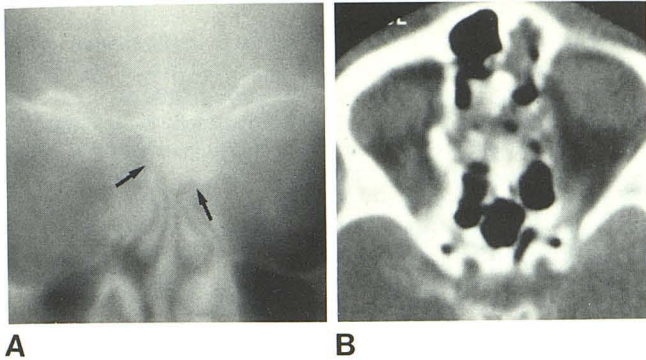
Right posttraumatic rhinorrhea, case 15. A, Frontal polytomogram. Left clouded ethmoidal cells (arrows) but no patent abnormality of lamina cribosa. B, Axial CT cisternogram with Iopamidol. Bilateral opacity in upper ethmoid cells.
